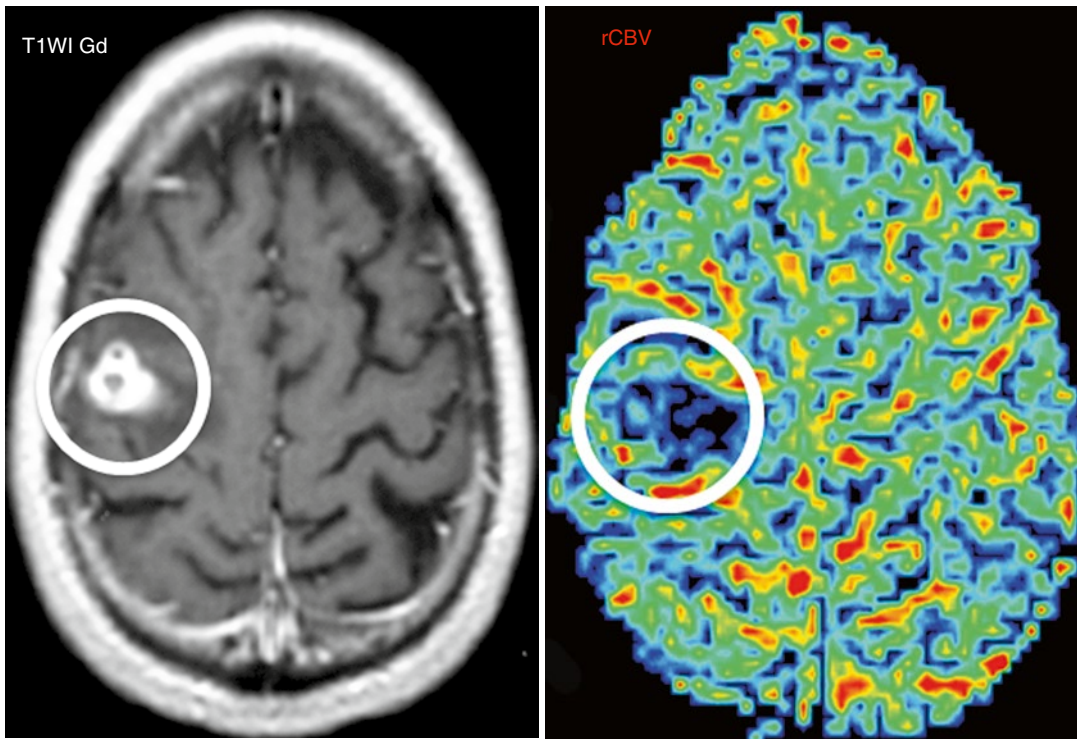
HIV-positive patient with toxoplasmosis presented a round-enhancing lesion (*circle on left image*) that does not present high rCBV on DSC-MRI (*circle on right image*)
